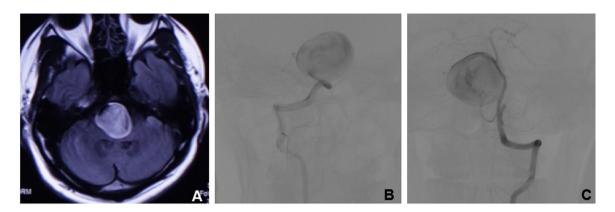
A vertebrobasilar junction giant saccular aneurysm. A 58-year-old man presented numbness. (A) Axial T1 MR imaging scan showed a giant mass in front of the pons. (B) Right vertebral artery angiogram showed a giant saccular aneurysm and the absence of basilar artery. (C) Left vertebral artery angiogram showed that the blood supply of left vertebral artery was not sufficient. This patient received conservative treatment because of a technical failure during the endovascular procedure. He died of aneurysmal rupture 6 months later.
